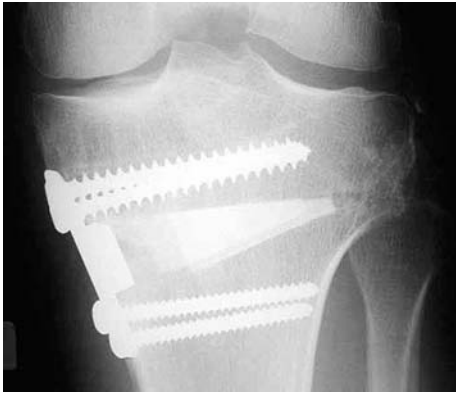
Postoperative radiograph of an opening wedge high tibial osteotomy in a 42-year-old man. The osteotomy was filled with a tricalcium wedge and fixed with an Arthrex-Puddu plate
